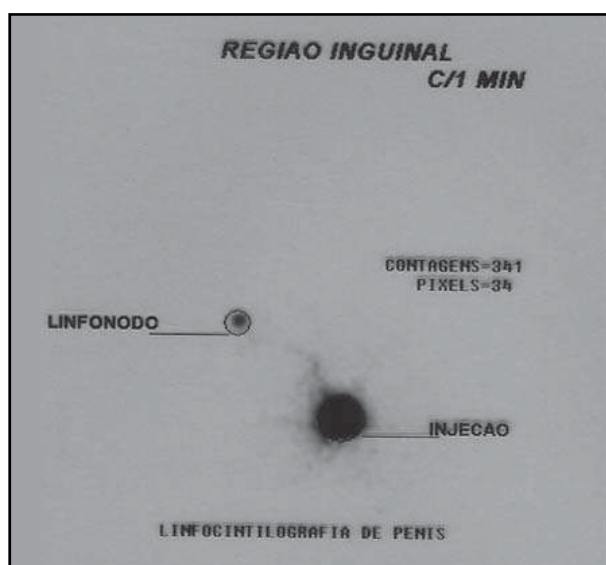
Pre-operative lymphoscintigraphy after injection of the primary tumor with ⁹⁹technetium labeled sulfur colloid
